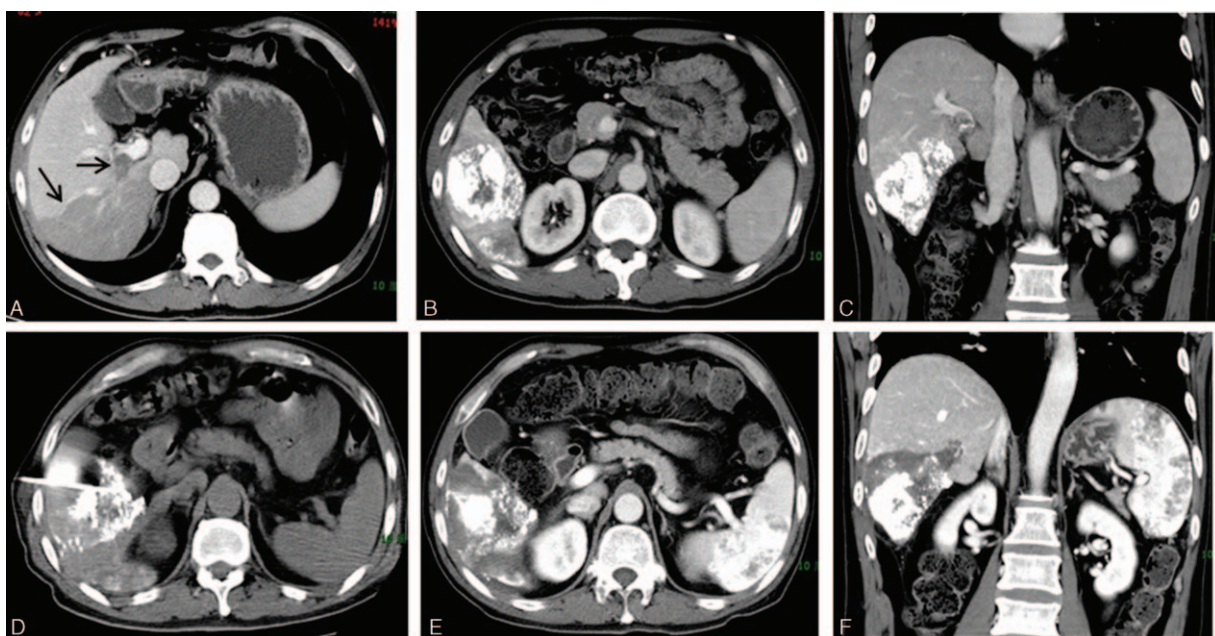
Computed tomography (CT) scanning of a patient treated by CT-guided percutaneous segment VI ablation therapy. (A) Preoperative contrast-enhanced CT scan of the liver tumor mass. Black arrow: tumor mass and tumor thrombus in portal vein. (B, C) CT scanning images after TACE. The tumor mass was labeled by iodized oil injected via TACE. (D) Intraoperative CT scan of the ablation against segment VI. (E, F) Postoperative contrast-enhanced CT scan at 1 month after the ablation therapy. The tumor-containing segment VI was completely ablated.
